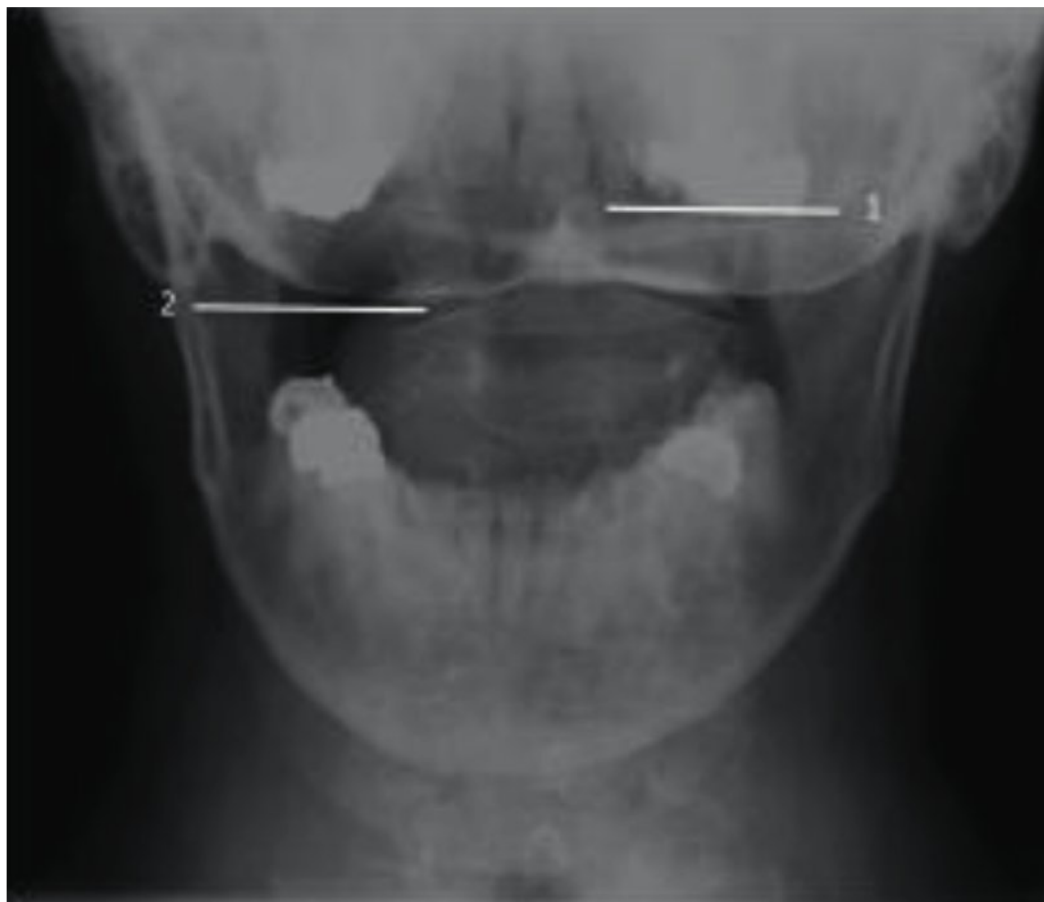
Radiograph, open-mouth view. 1, dens; 2, atlantoaxial joint.
